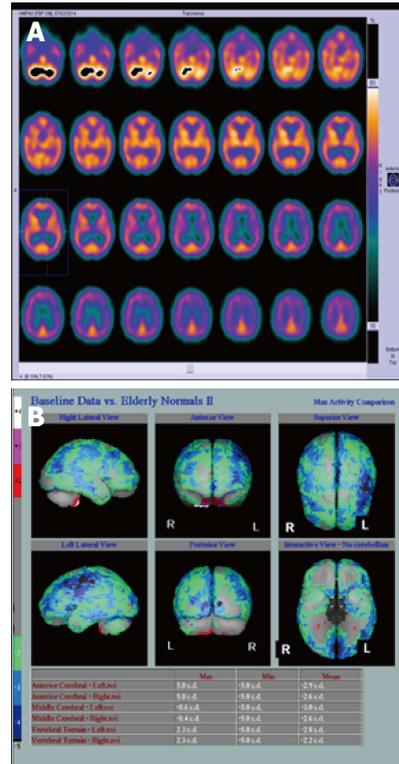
Hexamethylpropylene amine oxime single photon emission computed tomography in a patient with mixed vascular disease and Alzheimer's disease. A: Shows reduced perfusion in both the frontal and parietal lobes, especially on the left; B: Parametric images providing an overall view. There was hippocampal atrophy on computed tomography (Images kindly prepared by Dr. Fergus McKiddie).
